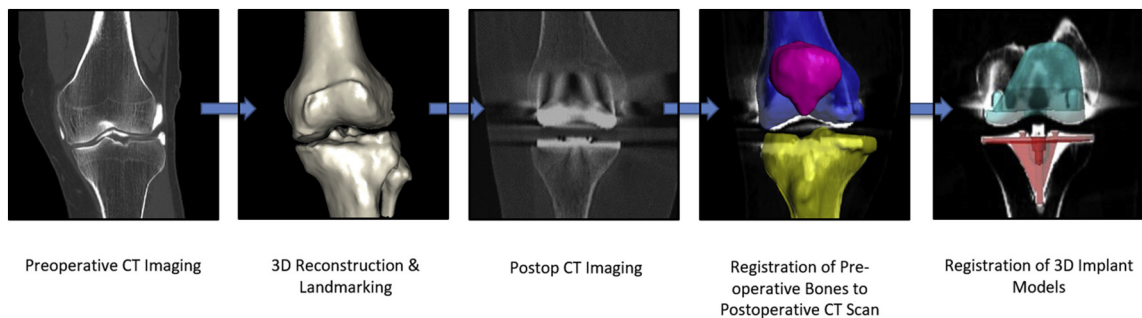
The process used to accurately determine the placement of the components. CT, computed tomography; 3D, three-dimensional.
